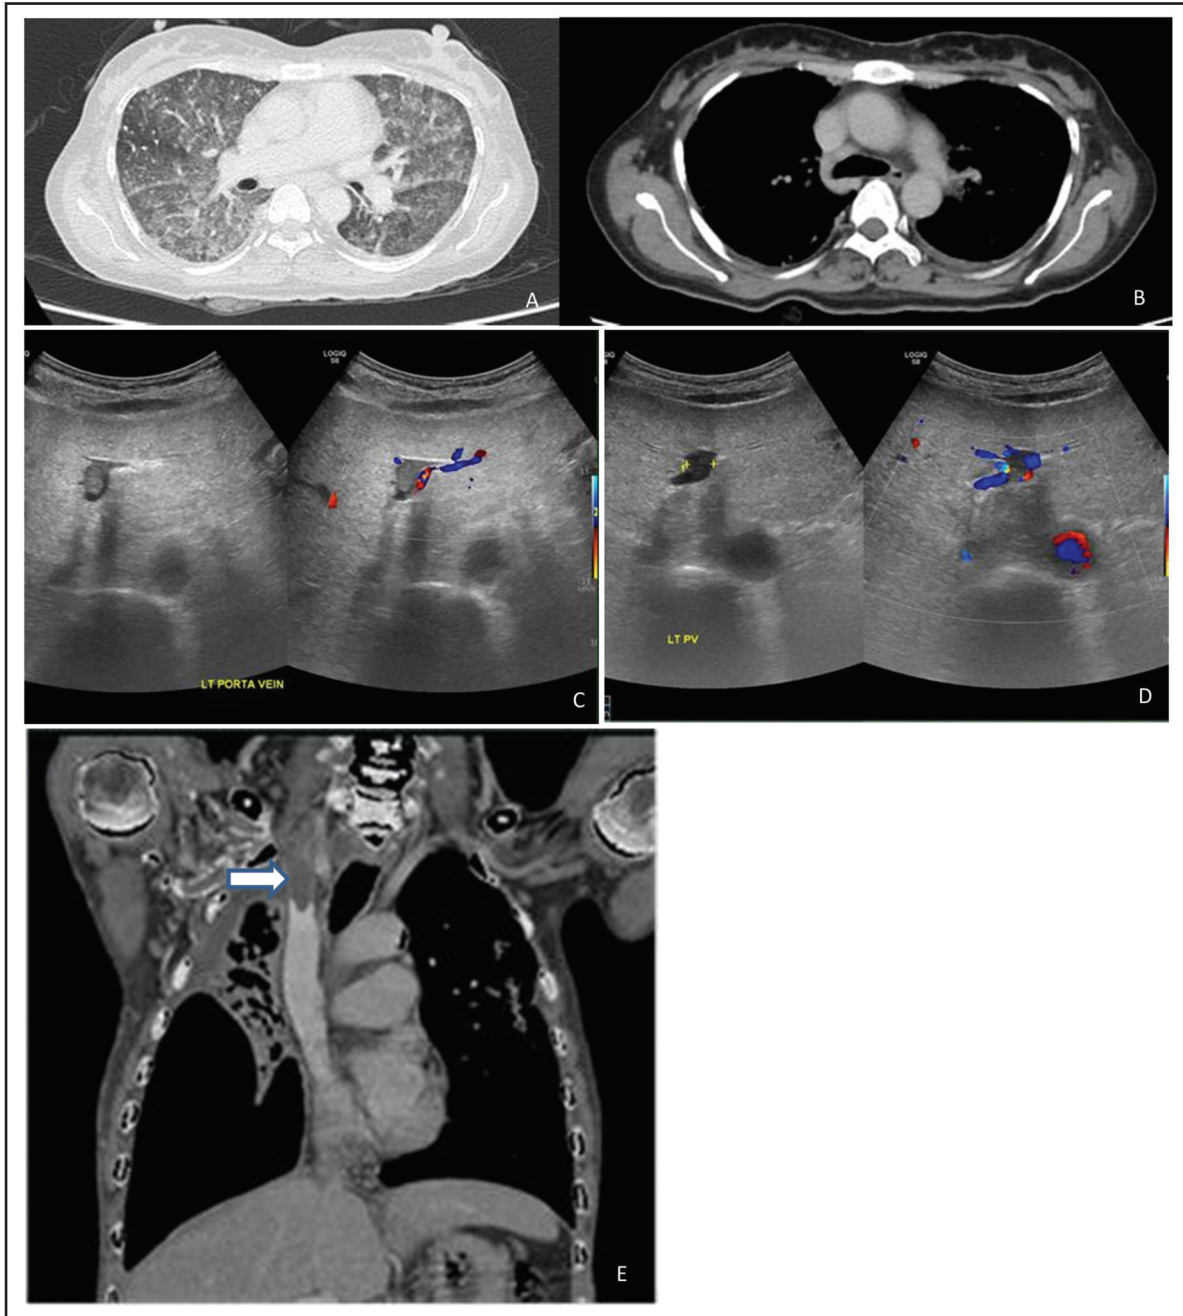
(A) CECT thorax showed multiple small lung nodules, ground glass opacification in both lungs. (B) . CECT thorax showed mediastinal lymphadenopathy. (C&D) USG Doppler of the portal vein showed residual thrombosis at 2 weeks' interval. (E) CECT thorax showed filling defects in right brachiocephalic, right internal jugular, subclavian and axillary veins.
